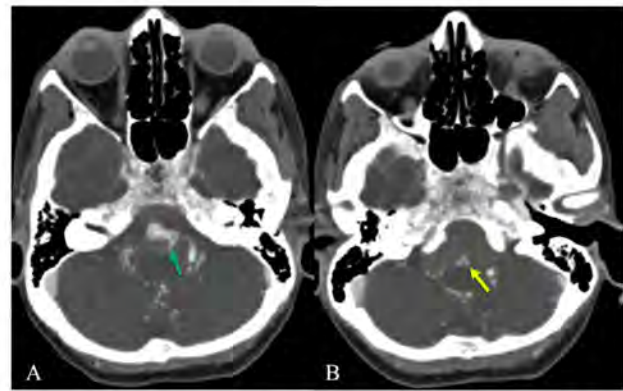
CT Angiography Demonstrating Left Vertebral–Anterior Spinal Artery Junction Aneurysm
